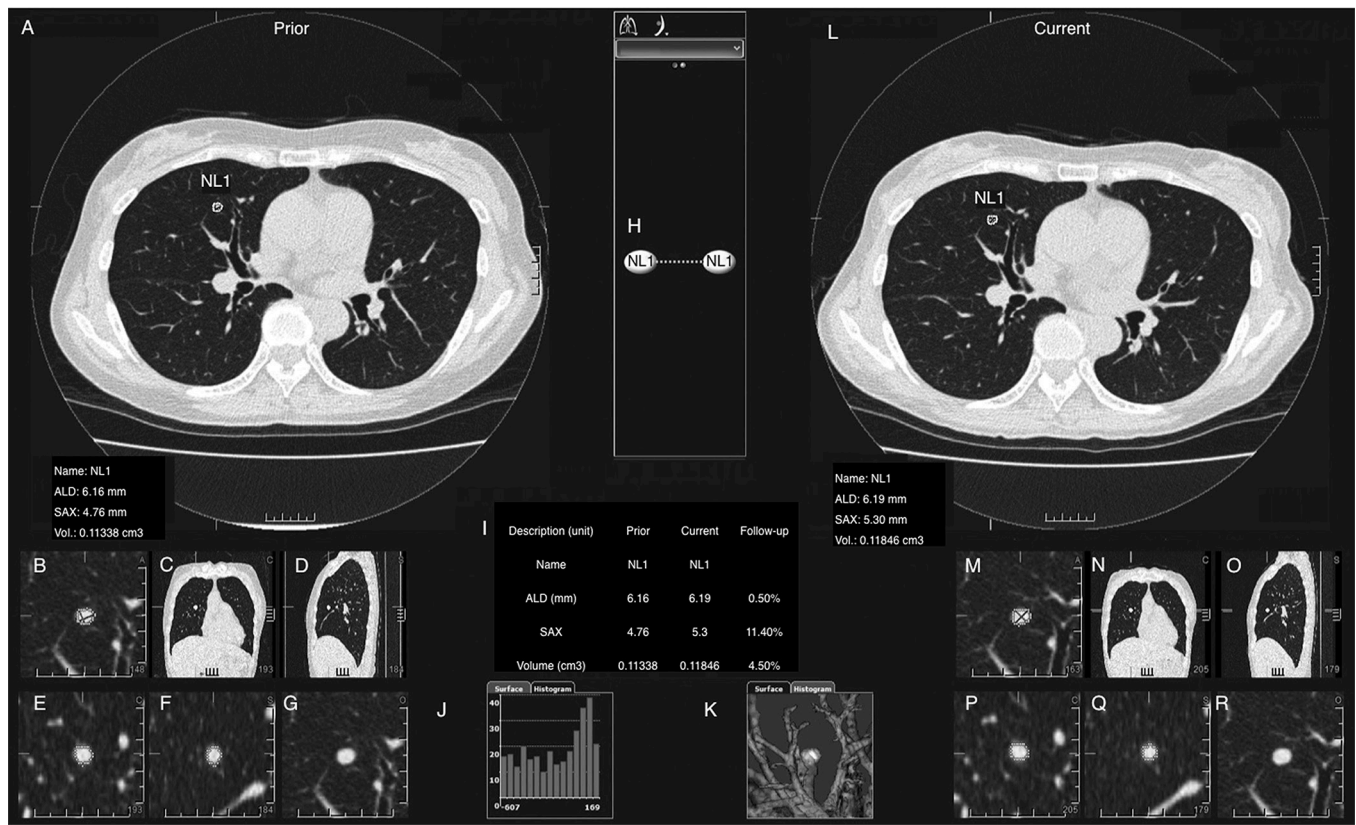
User interface of the LMS. A solid nodule was located in segment 5 of the right middle lobe. The axial CT image on the left (A) was taken 1 year prior to the axial CT image on the right (L); the measurement results were shown in left lower corner of each axial CT image; (B,M) axial zoom with diameter measurements; (C,N) coronal view; (D,O) sagittal view; (H) matching of CT slices on which the nodule exists; (I) table for results of analyses; (E,P) coronal zoom of the nodule; (F,Q) sagittal zoom of the nodule; (G,R) axial zoom of the nodule; (J) histogram of the nodule in *Figure 2L*; (K) three-dimensional visualization of the nodule. NL1, nodule number; ALD, axial largest diameter; SAX, short axial diameter; Vol., volume; LMS, Lesion Management Solutions.
